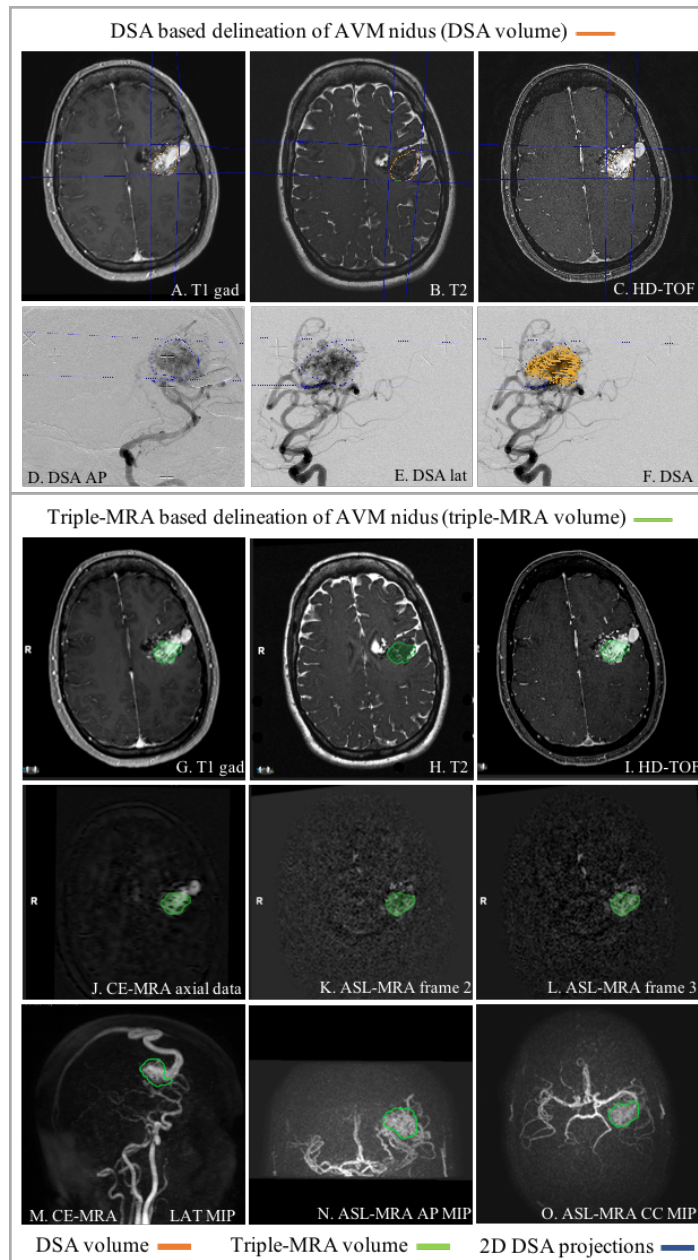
Imaging used for AVM delineation with the standard DSA based method and triple-MRA. Stereotactic DSA(D-F) together with standard volumetric MRI (top row) is the current reference standard for target delineation in AVM radiosurgery. The limits (blue lines) of an AVM ROI delineated on 2D DSA images (blue contour) are projected into volumetric MRI defining an area within which the AVM is contained. A 3D volume is then drawn within this area on volumetric scans (DSA volume, orange). Definition of an AVM volume on triple-MRA (bottom three rows) is based on co-registered MRA sequences: ASL MRA (K-L), CE-MRA (J) and HD-TOF (I) together with routine volumetric MRI. A 3D volume is drawn including areas shown to be part of the AVM nidus on all co-registered multimodality images and the resultant triple-MRA volume (green) is displayed on 360 degrees of freedom MIPs of the MRA sequences (bottom row).
